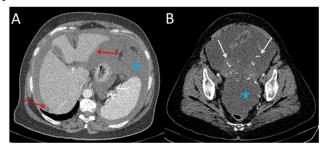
A and B: axial CT scans of the abdomen revealing diffuse ascites (stars) with scalloping on the liver surface (red arrows). Note the calcifications within the pelvic masses.
